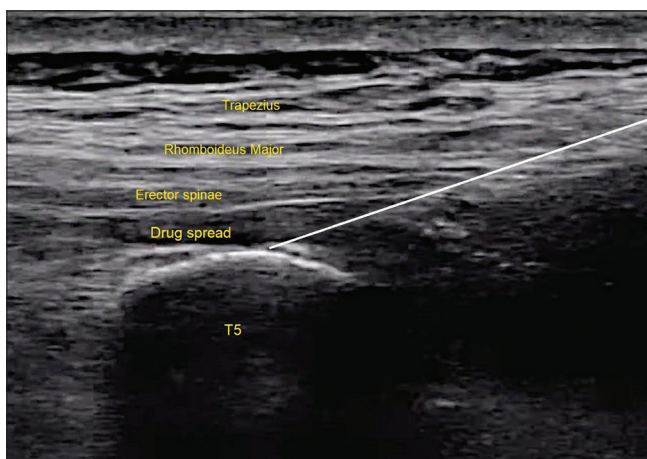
Ultrasound image of erector spinae plane block (ESPB)
